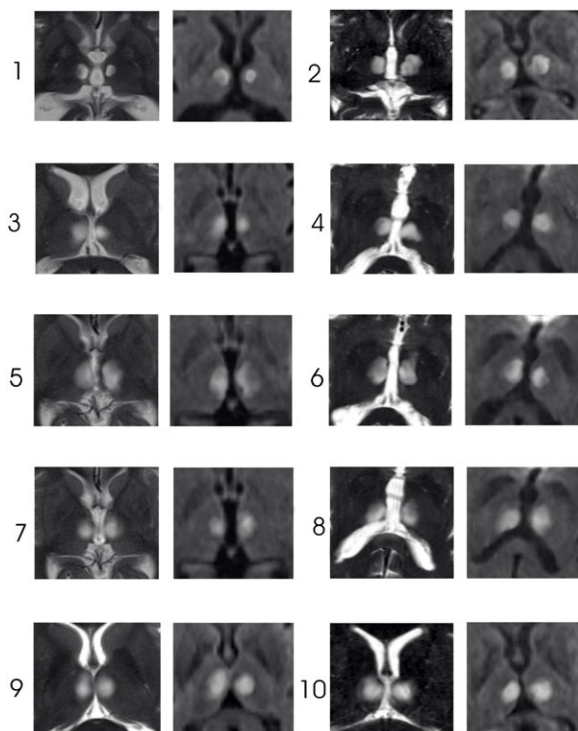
T₂-weighted and DWI images (axial reconstructions) of the thalamus show the pattern of artery of Percheron territory infarct. Notice involving of the variant and classical lesions in each patient. Images are cropped to display the thalamus only.
